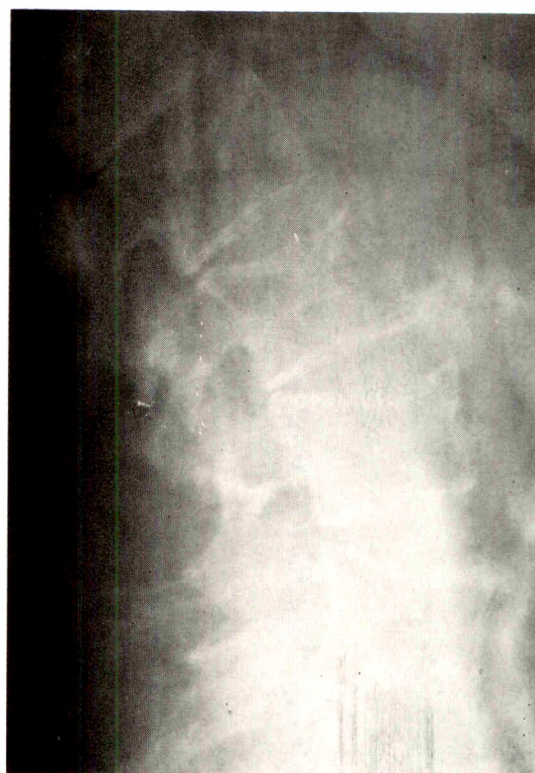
Case III. Lateral roentgenogram of the lumbar spine showing partial collapse of L2-L5 and concavity of superior end plates.
